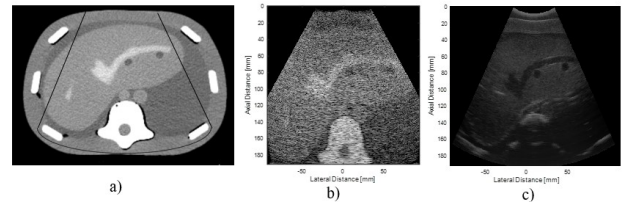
Comparison between (a) ground-truth CT slice with chosen sector ROI marked with a black solid line, (b) ultrasound image generated through Field II, and (c) ground-truth ultrasound image that was acquired experimentally.
